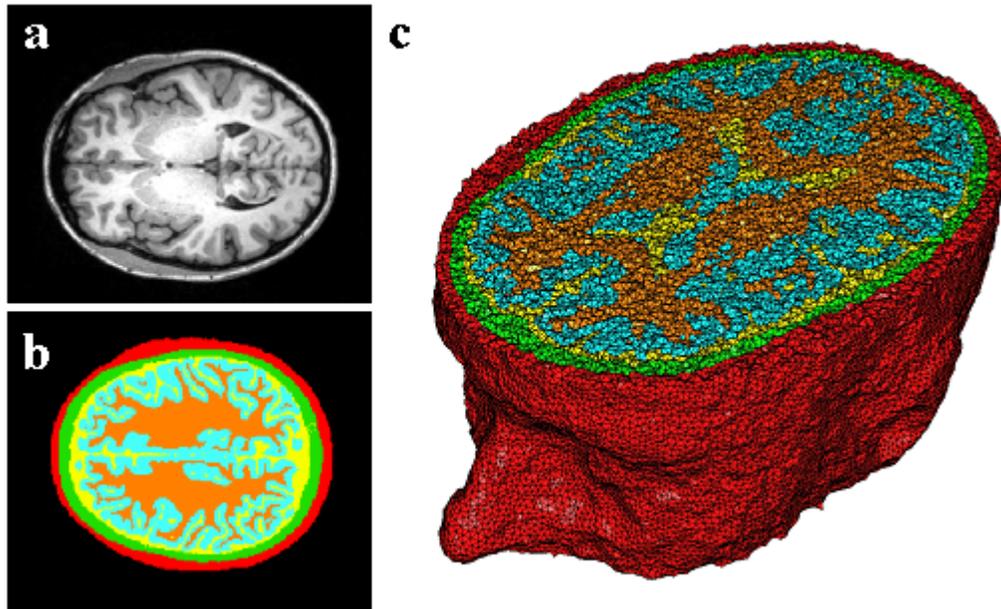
(a) Original MRI axial slice of the brain, (b) segmentation of different tissue types, and (c) the 3D tetrahedral mesh for the brain, showing the regions as different colors: red is the skin, yellow is the cerebral spinal fluid, green is the skull, blue is the white matter, and orange is the gray matter.
